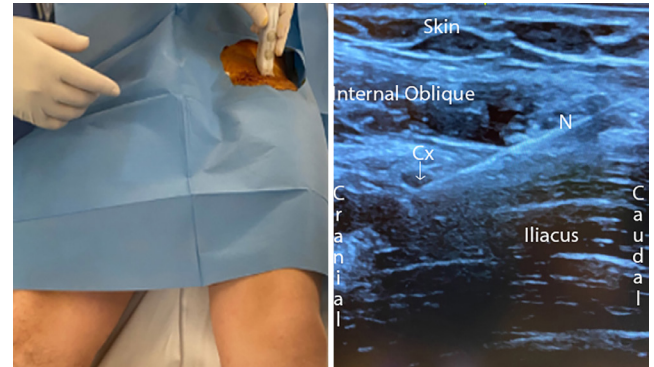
Orientation of the probe (left). Ultrasound image of the block (right).
